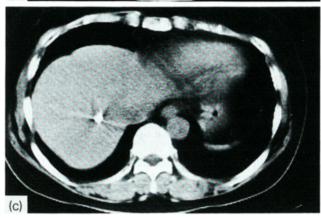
Patients considered to be cured. (a) CT scan, 7 days after initial administration. (b) CT scan, 13 months after first dose. The mixture of oily anticancer agents was given six times during this period. (c) CT scan, 36 months after initial administration. The patient is alive and well 5 years after the initial dose.
